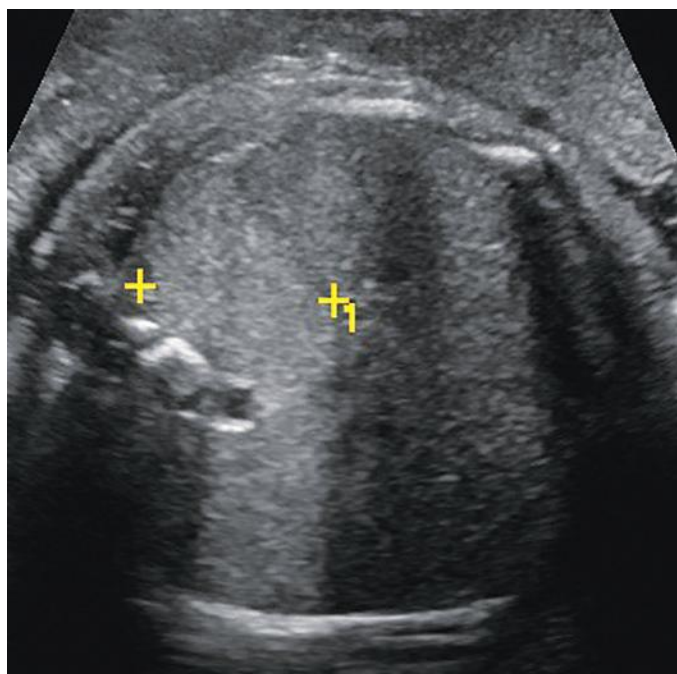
Axial sonographic image through the fetal upper abdomen demonstrating a subdiaphragmatic sequestration.
